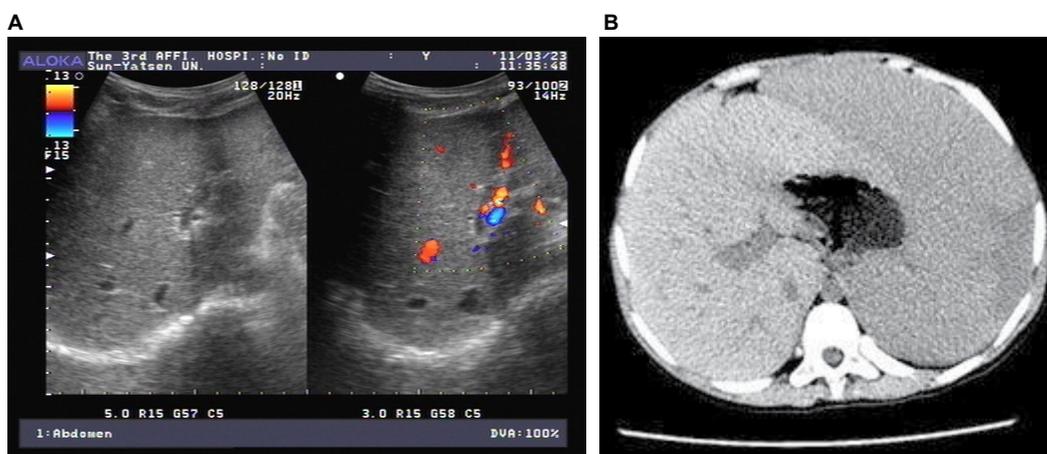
A. US and B. CT show grossly enlarged spleen.
